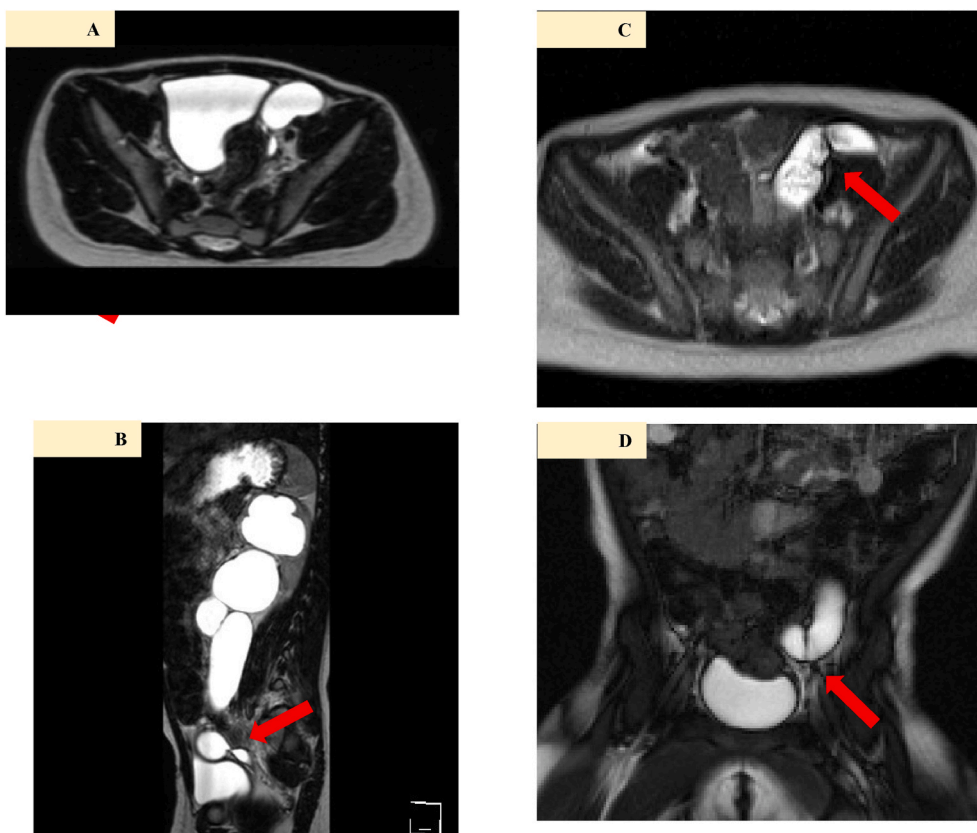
Postoperative magnetic resonance imaging reveals mid-ureteral stricture. Coronal (A), Sagittal (B). Looking back at the preoperative magnetic resonance imaging, pleated findings were found (C), (D).
